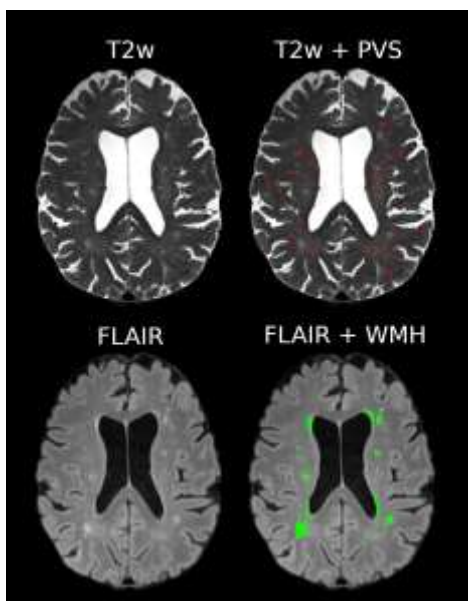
PVS and WMH segmentation methods. The figure displays an axial section at the level of the centrum semiovale from a 76-year-old male patient. PVS and WMH are depicted on T2-weighted and FLAIR sequences, respectively.
